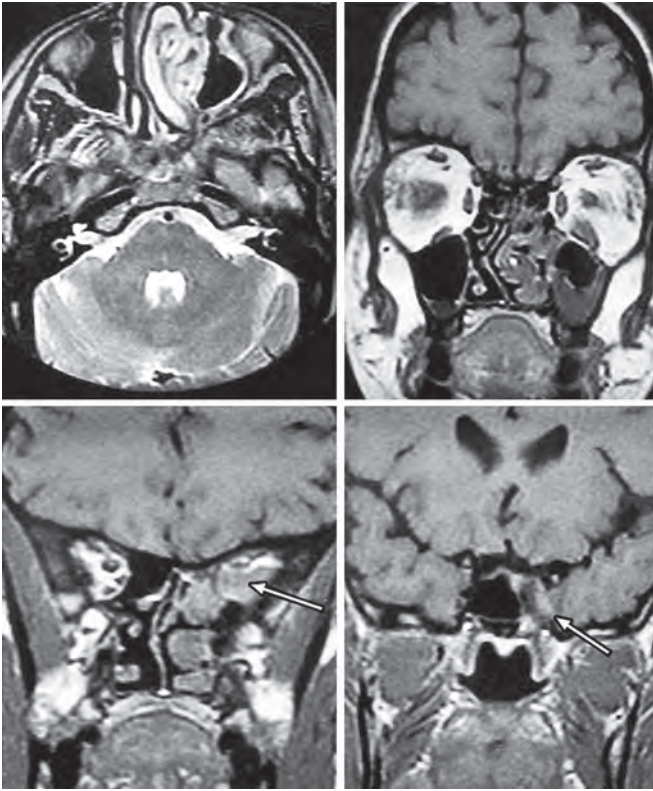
MRI of the brain showing pansinusitis with erosion of the bone and without dural breach or parenchymal spread (Stage II)
